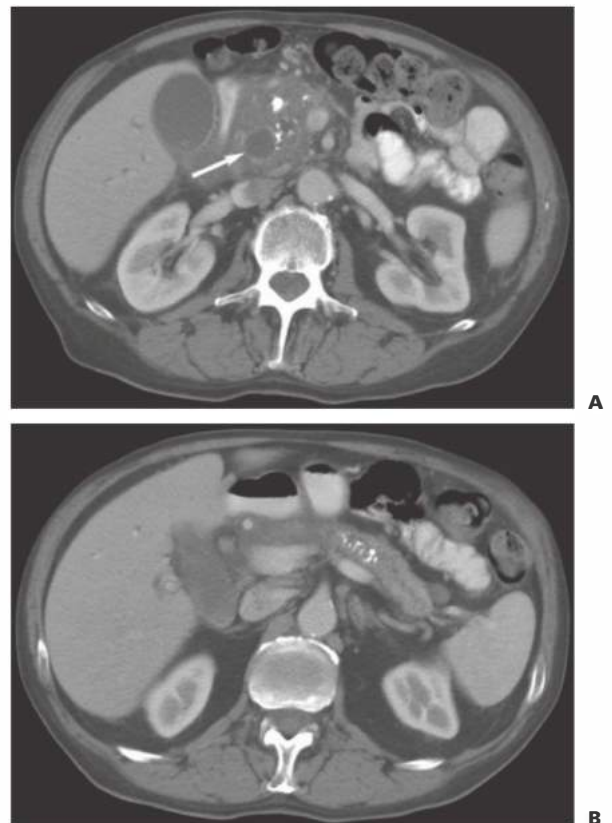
• A. CT of the abdomen demonstrating an enlarged head of the pancreas with multiple calcifications indicative of alcoholic chronic pancreatitis. A small pseudocyst is also noted in the head (arrow). B. The distal pancreas contains calcifications and a dilated pancreatic duct.
